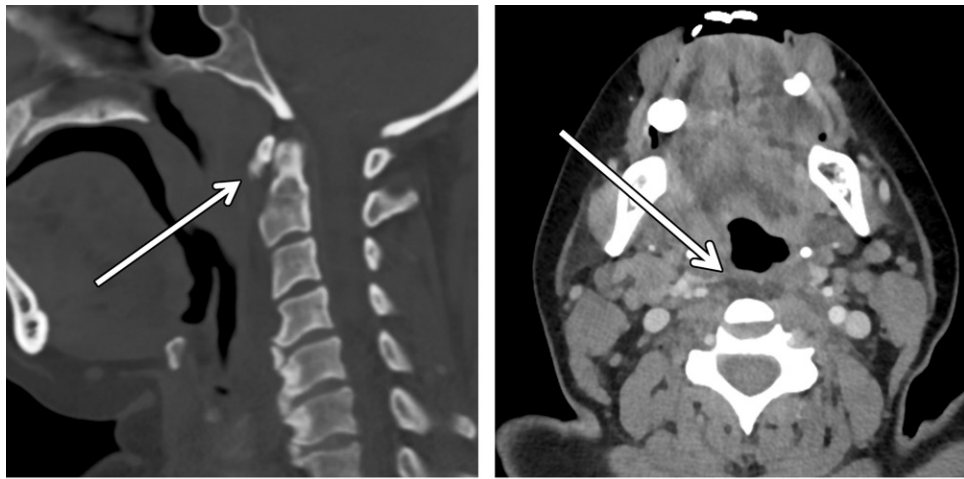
Longus colli calcific tendinitis in a 47-year-old man with transient pain and tenderness over the right middle neck. (a) Sagittal CT image (bone window) shows amorphous calcification (arrow) at the insertion of the longus colli tendon near the anterior arch of the C1 vertebra. (b) Axial contrast-enhanced CT image shows hypoattenuating effusion (arrow) in the prevertebral space without surrounding enhancement.
